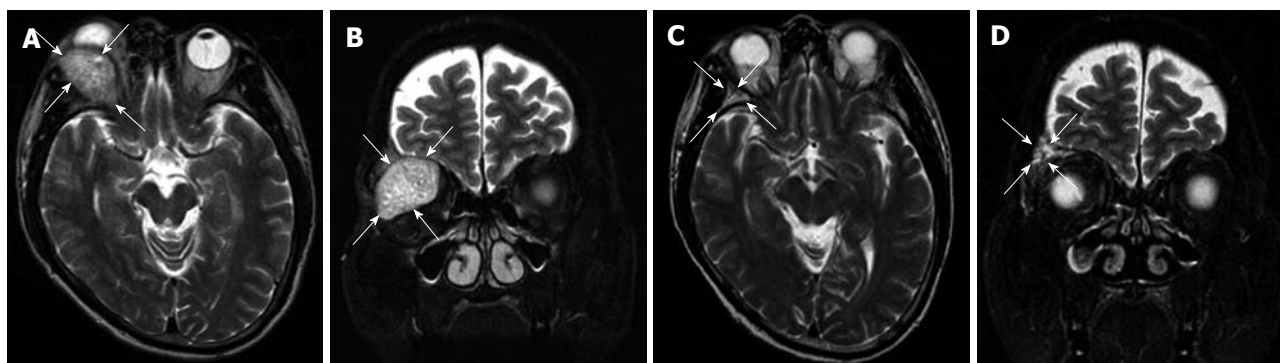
Axial (A) and coronal (B) T2 weighted MRI of the brain demonstrating the large soft tissue mass in the superior and lateral aspect of the right orbit (white arrows) prior to radiation treatment and resolution of mass on follow-up MRI 12 mo after treatment on axial (C) and coronal images (D).
